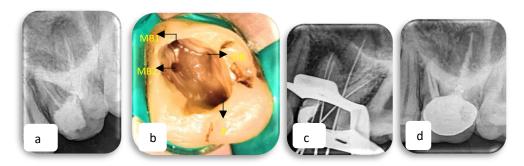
Non-surgical Endodontic Retreatment of Maxillary Right First Molar. a) Preoperative Radiograph; b) Access Cavity Preparation; c) Working Length Radiograph; d) Post operative Radiograph.
